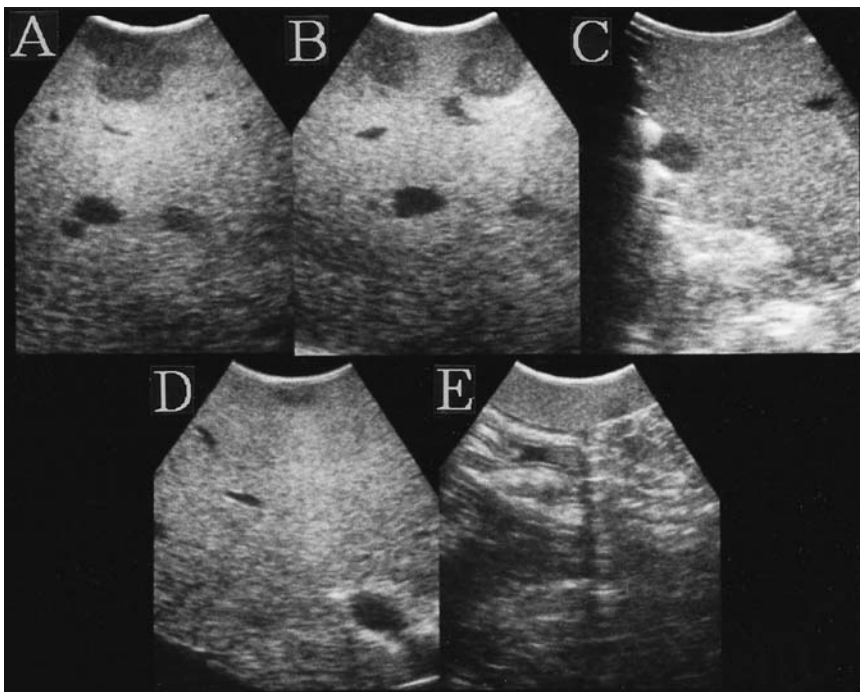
Intraoperative ultrasonography images at the second hepatectomy. Out of the 16 nodules identified intraoperatively, 7 were revealed: 4 nodules in segment 8 (A,B), 2 in segment 4 (C,D), and 1 in segment 6 (E)
